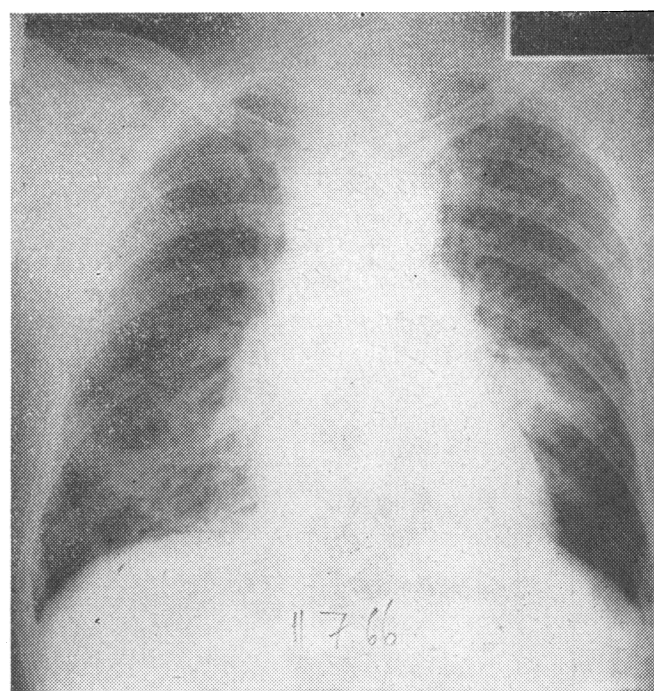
Chest radiograph on 11 July 1966.
